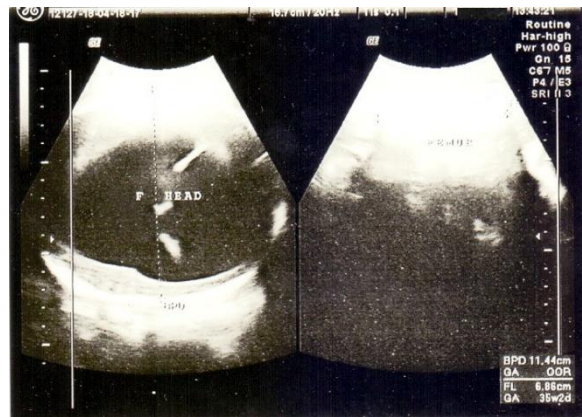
The sonogram shows the transverse view of the fetal head at the level of the third ventricle with total loss of visible landmarks for measuring Bi-Parietal Diameter (BPD), which was 11.4 cm as seen in the lower-left quadrant of the image. The Femoral Length (FL) was 6.86 cm, and the estimated gestational age was 35 weeks and 2 days. Observe the internal echoes and the reverberating dotted hyperechogenic artefact.
